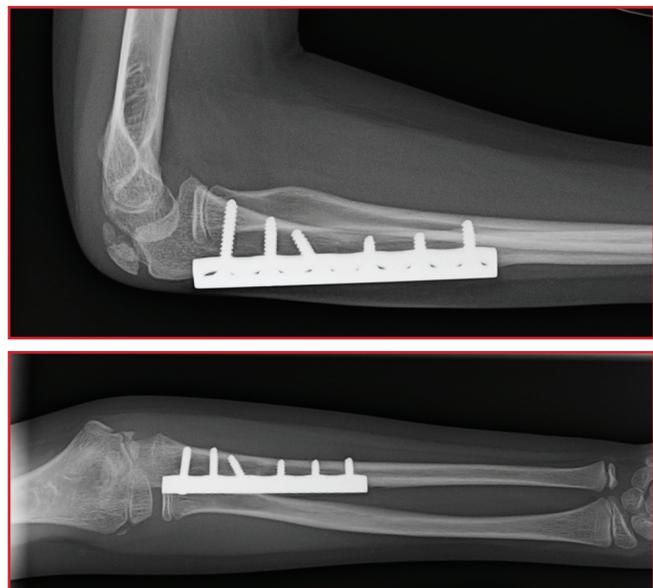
Ten month post-operative x-ray after ulnar osteotomy showing healed osteotomy and maintained concentric reduction of the radial head
